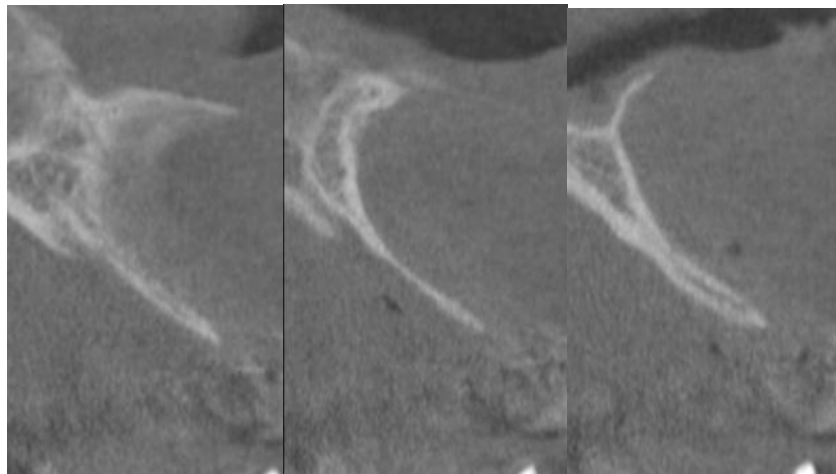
CBCT sections with respect to 21.
